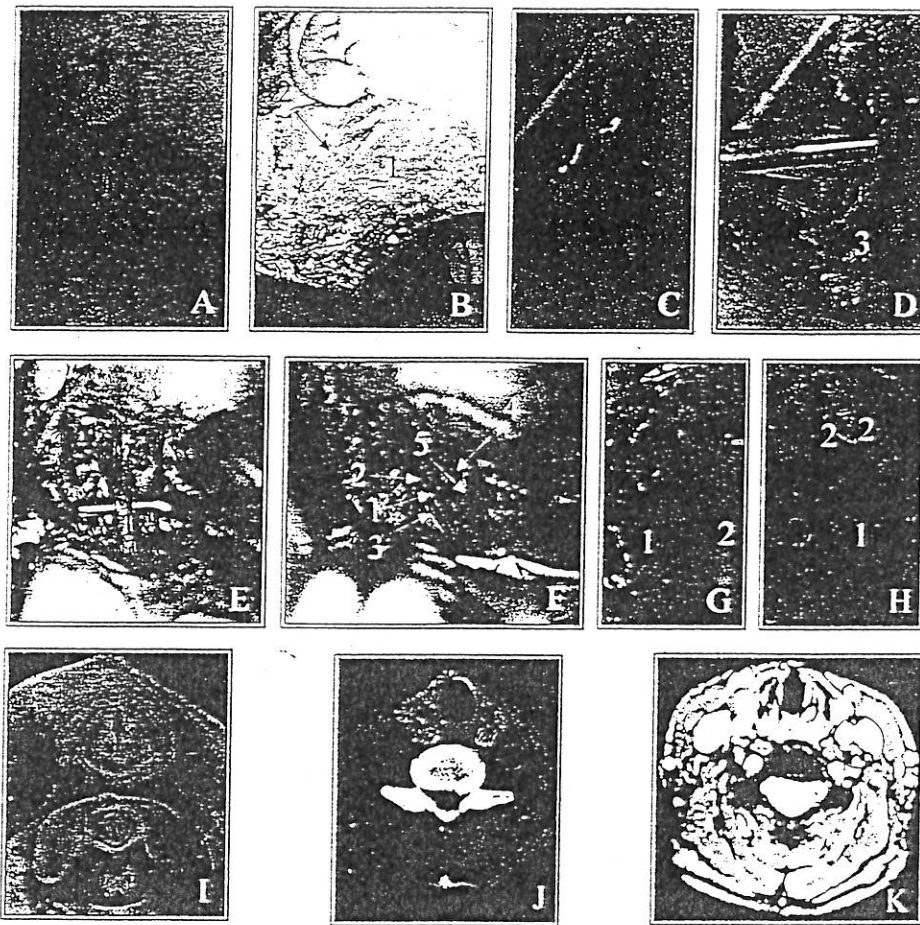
Sternocleidomastoidea region and its content: A) 1 cutaneous plane; B) subcutaneous plane: 1 m. platysma, 2 external jugular v.; C) musculus fascialis superficialis plane: 1 m. sternocleidomastoideus, 2 fascia cervicalis superficialis; D) musculus fascialis profundus plane: 1 m. omohyoideus, 2 m. sternohyoideus, 3 fascia cervicalis media; E) fascium vasculonervosum and vagina vascularis (1); F) vascular and visceral space: 1 common carotid a., 2 internal jugular v., 3 n. vagus, 4 larynx trachealis canal, 5 glandula thyroidea; G) deep plane of vascular and visceral spaces: 1 mm. vertebralis, 2 columna vertebralis and fascia cervicalis profunda; H) common carotid artery and its bifurcation branches; I) platinated section: fascium vasculonervosum (in the circle); J) CT scan section: fascium vasculonervosum (in the circle); K) MR scans: fascium vasculonervosum (in the circle);
